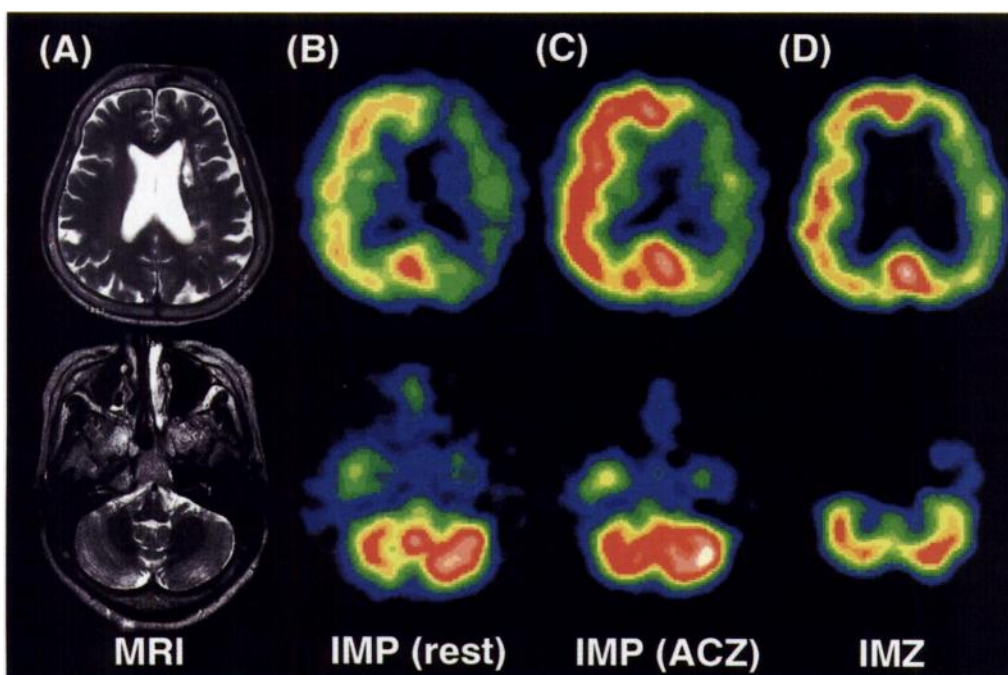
(A) MR and (B-D) SPECT images for Patient 9. (A) MRI revealed a subcortical infarction in the left corona radiata, with no involvement of the cortical area. (B) Iodine-123-IMP SPECT in the resting state revealed severe low perfusion in the left MCA territory and right cerebellum. (C) After acetazolamide challenge, markedly decreased perfusion reserve in the left cerebral hemisphere was observed. (D) Iodine-123-iomazenil SPECT revealed moderately low accumulation in the left MCA territory. The asymmetry of uptake in the cerebellum with ^{123}I -iomazenil was less prominent than that with ^{123}I -IMP.
